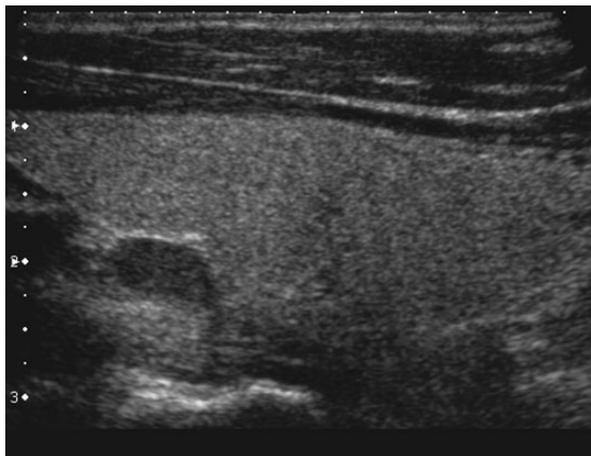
Thyroid gland B-mode ultrasonography revealing parathyroid gland hypertrophy of the right upper gland in a dialysis patient with uncontrolled hyperparathyroidism: the parathyroid gland is easily distinguishable as positioned behind the thyroid, oval in shape, with a hypoechoic pattern, when compared with the neighbouring tissue of the thyroid gland.
